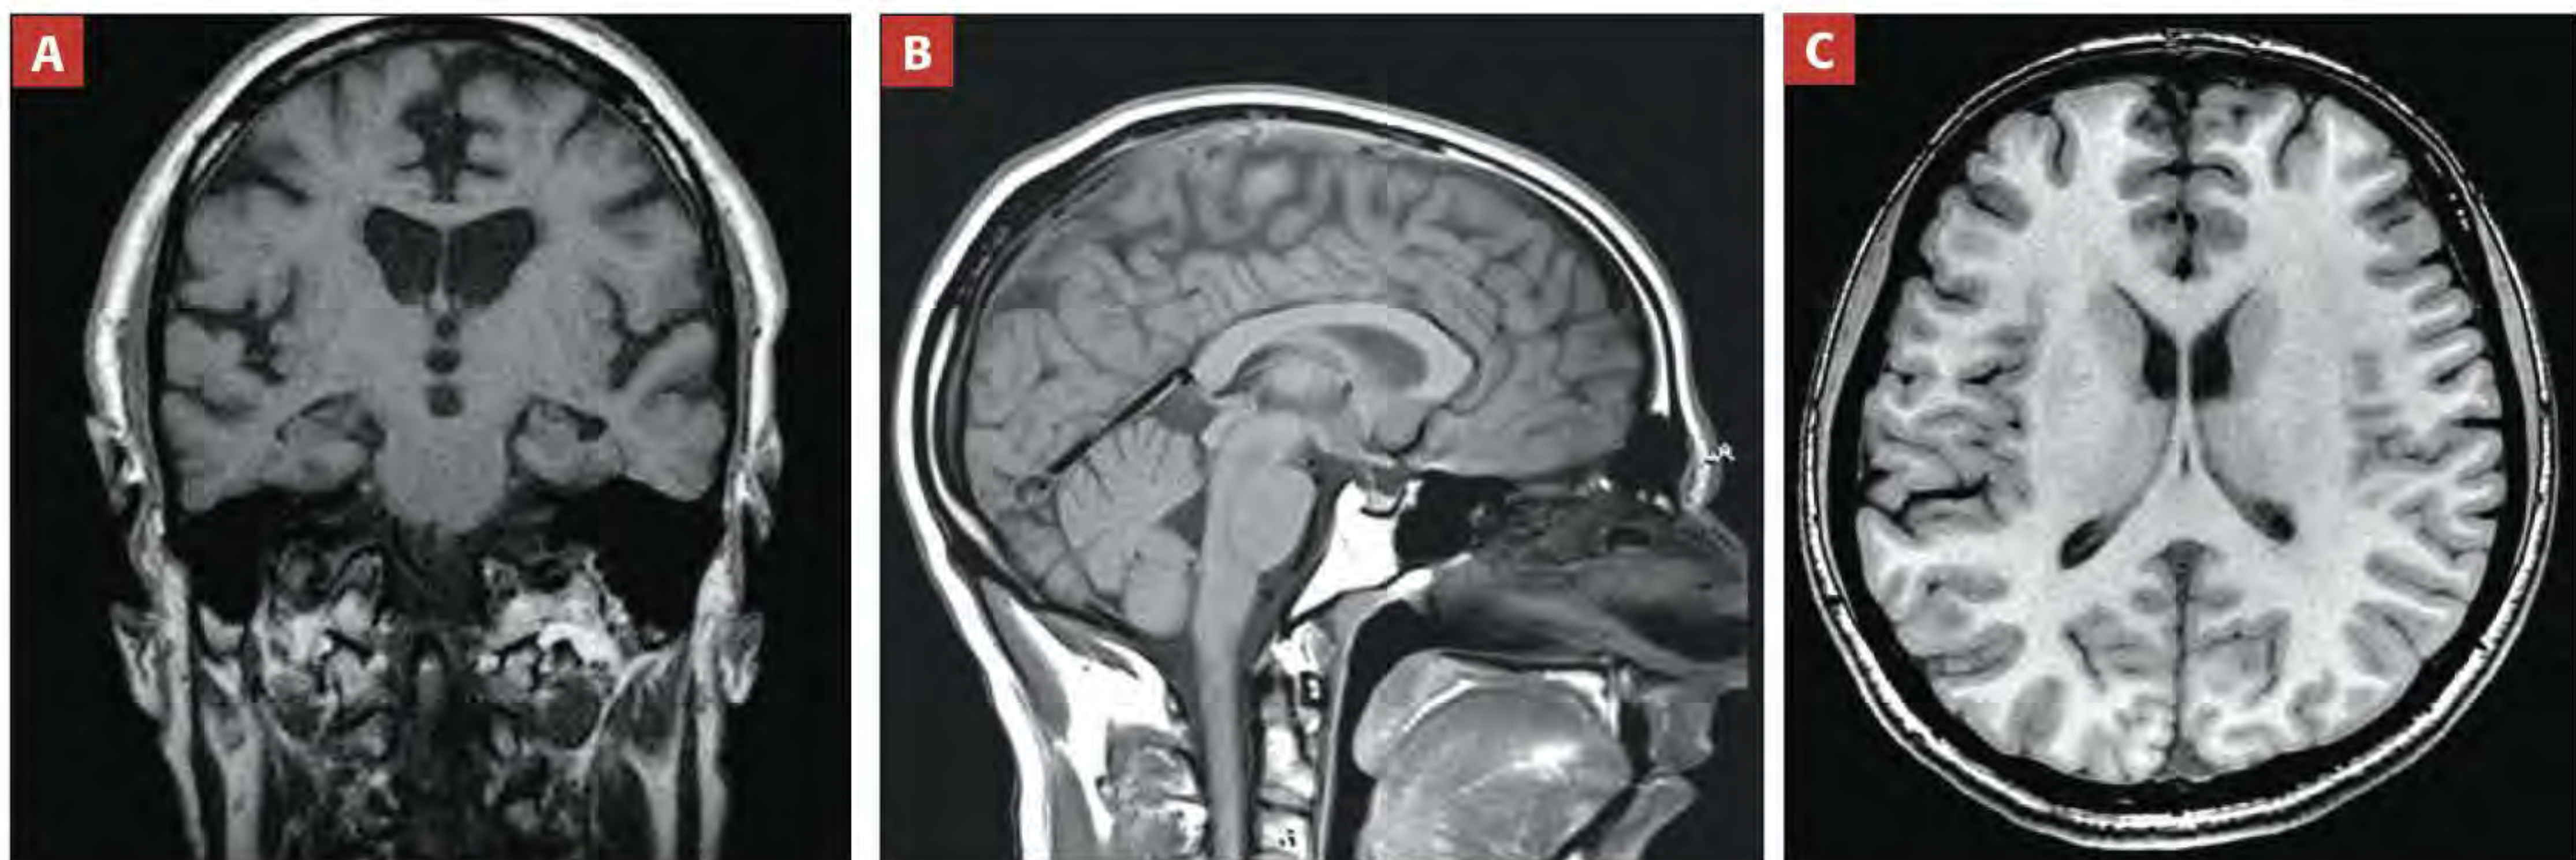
Planes of anatomical section visible on computed tomography scans of the brain: (A) frontal section; (B) midsagittal section; (C) transverse section.
